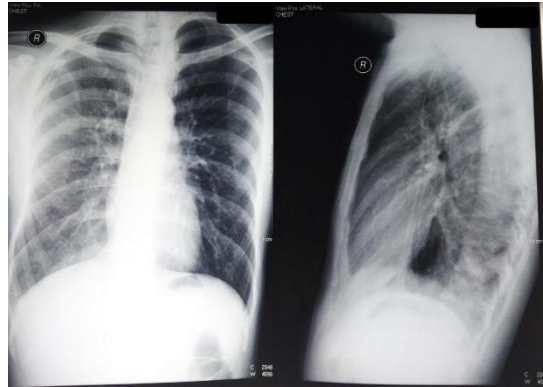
The chest X-ray of patients on the second day showed that the infiltrate in the right lung when compared with the previous photo was reduced.
